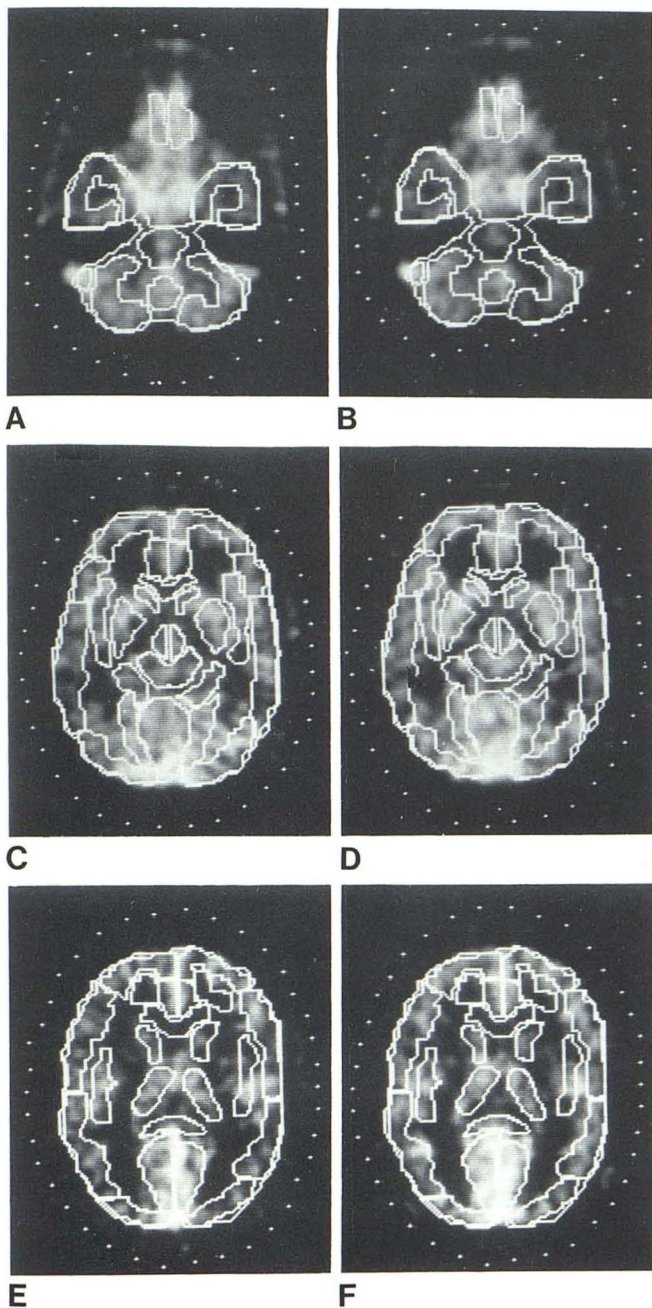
Regions of interest (ROIs) selected from CT and transferred onto PET images. The same areas are used twice, at first examination (A, C, and E) and after treatment with neuroleptic drugs (B, D, and F). Note reproducibility at patient alignment. Fixation system enables automatic transfer of ROIs from CT to PET and repeat use of ROIs.
